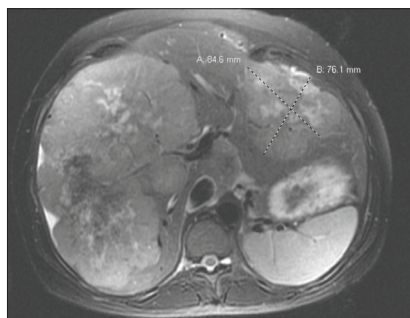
Initial CT scan for a 33-year-old otherwise healthy woman demonstrating significant liver replacement by tumor. The majority of liver segments are involved, including the caudate lobe.
